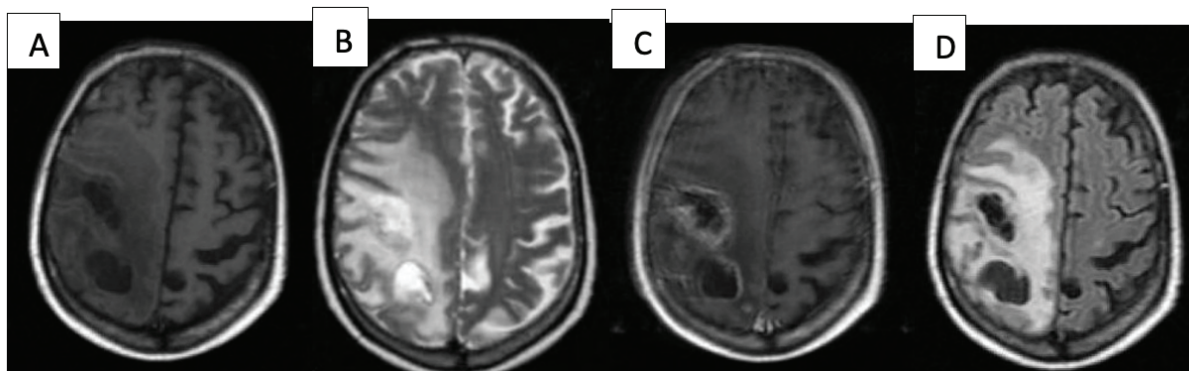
The patient underwent brain magnetic resonance imaging [(A) T1 weighted, (B) T2 weighted, (C) T1weighted with contrast, (D) fluid-attenuated inversion-recovery images] and it revealed a right frontoparietal necrotic mass with peripheral edema and incomplete ring enhancement with areas of patchy enhancement.
